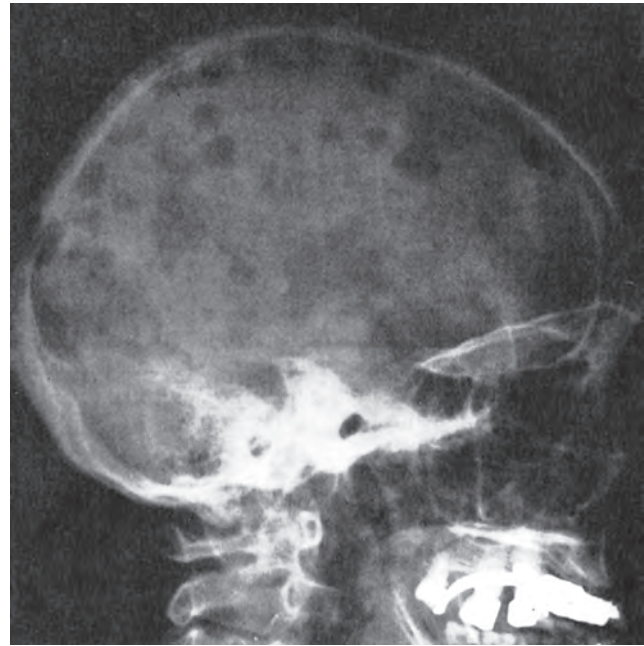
Multiple myeloma of the skull (radiograph, lateral view). The sharply punched-out bone lesions are most obvious in the calvaria.
